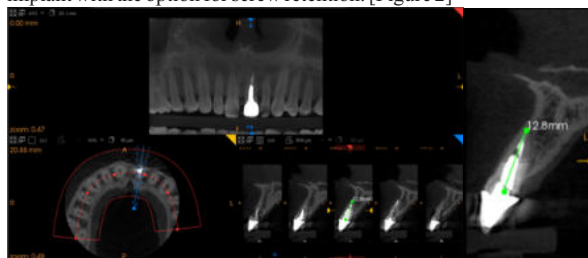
CBCT Of The Maxillary Arch, Specific To Fractured Central Incisor (21)
